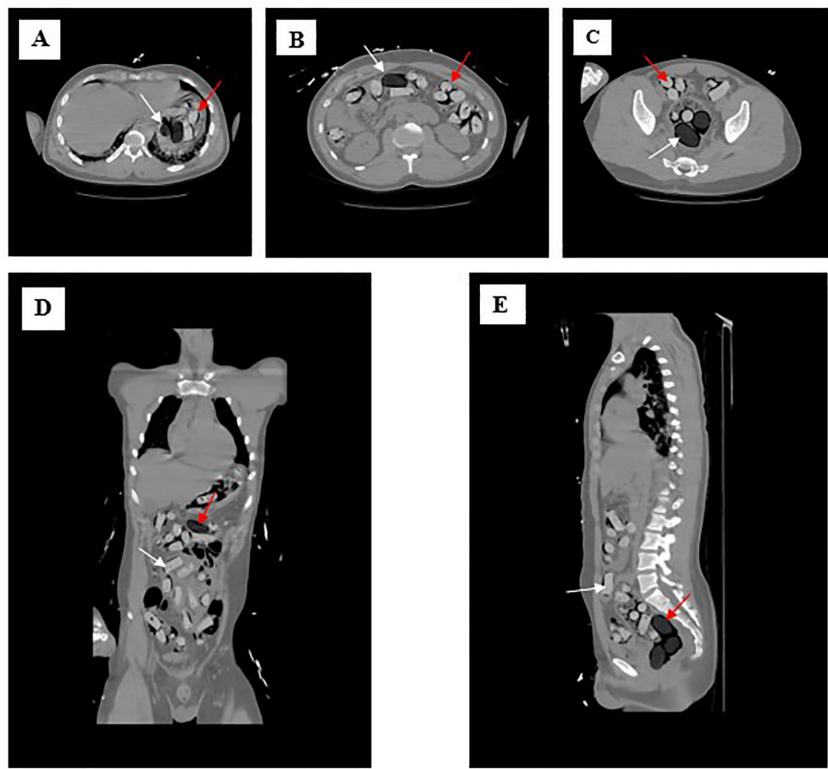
Abdominal computed tomography images of case 1 in axial (A, B and C), coronal (D), and sagittal (E) sections (red arrow: capsules containing heroin, white arrow: capsules containing opium poppy)
